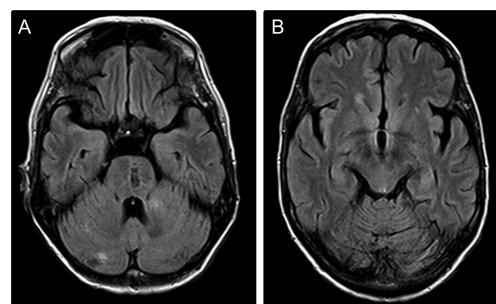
Brain MRI at 6 months' follow-up: Almost complete resolution of abnormalities after 6 months (A, B), but certain low-density areas are noticeable (A)
